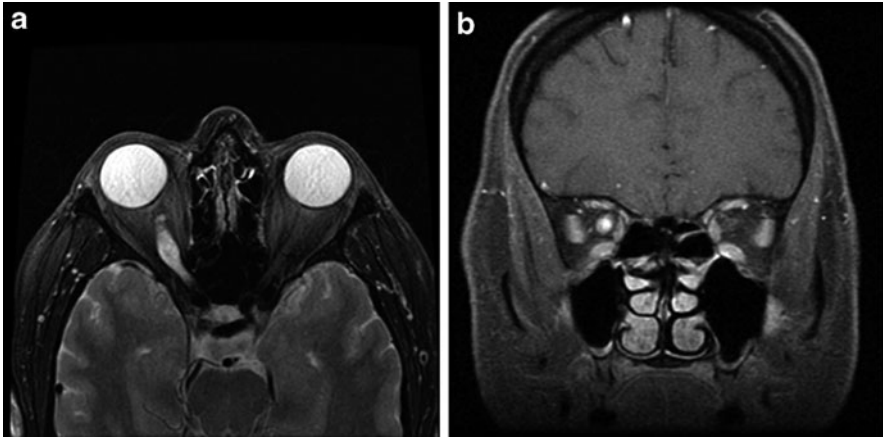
MRI glioma optic nerve OD: (a) axial and (b) coronal
